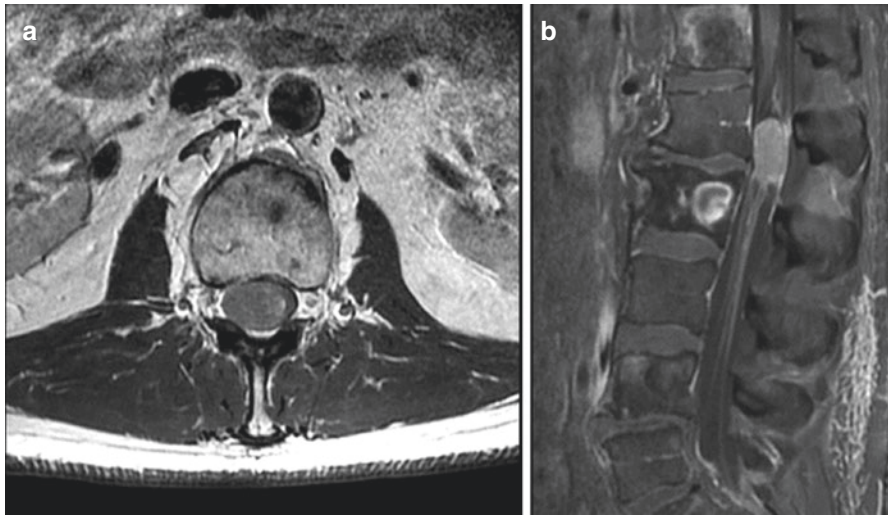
(a) T2-weighted axial MRI showing a large round tumor compressing the cauda equina. (b) T1-weighted sagittal MRI with contrast showing enhancing mass occupying the entire canal at L1–L2
